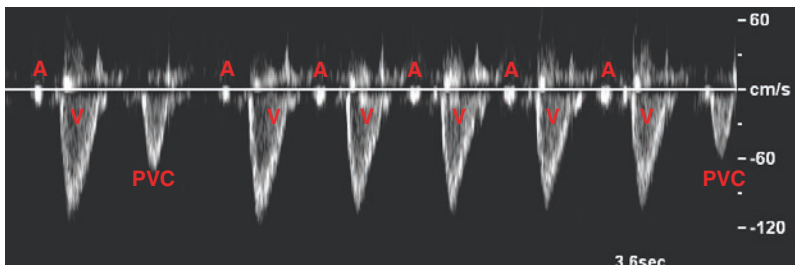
SVC–Ao Doppler showing normal beats and PVC. M-mode showing normal ventricular contraction and PVCs. Normal ventricular contraction is preceded by
